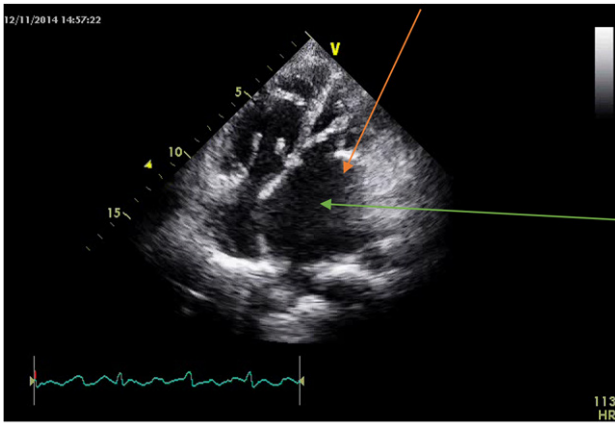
Echocardiogram image 1 - showing thickened mitral valve leaflets (orange arrow) suggestive of rheumatic heart disease, grossly dilated left atrium (green arrow)
